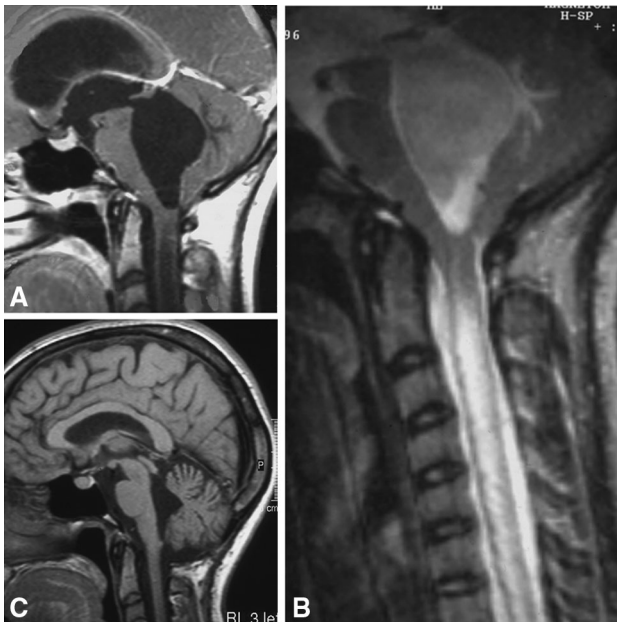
T1-weighted sagittal MR image showing syringomyelia associated with hydrocephalus. Note the “tight cisterna magna” (a). T2-weighted sagittal MR image showing cervical extension of the syrinx (b). The last postoperative image shows no evidence of the syrinx and patent opening between the fourth ventricle and the subarachnoid space, as demonstrated by the normal size of the ventricular system, the restoration of central nervous system morphology, and the subarachnoid space (c)
